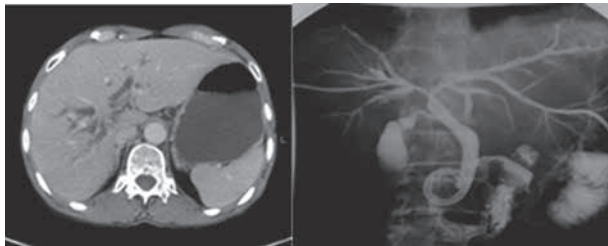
CT abdomen showing a small mass lesion at the confluence of the right and left hepatic ducts. The corresponding cholangiogram reveals a filling defect.
